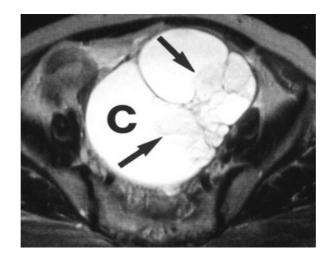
62-year-old woman with ovarian clear cell adenofibroma. Axial T2-weighted (TR/TE, 2,000/80) (A), axial T1-weighted (600/15) (B), and axial contrast-enhanced T1-weighted (C) MR images show large cystic mass with enhancing multiple septa and solid portions (*arrows*). C = cystic portions of mass.
